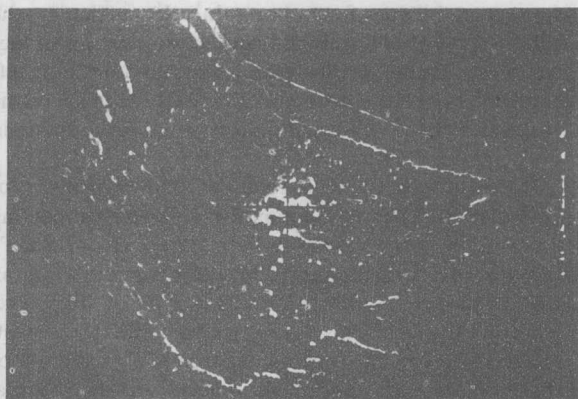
Bistable B-mode ultrasonogram through liver and right kidney. Notice all echoes are shown at the same intensity, and any small echoes below the threshold level, which can be adjusted, are lost from the scan.
